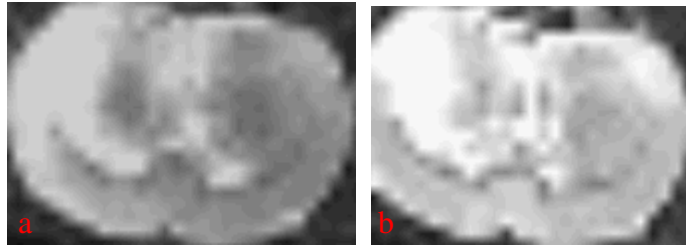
T2-weighted image showing final lesion 24 hrs after reperfusion, a: lesion both in cortex and striatum, b: lesion only in striatum.
